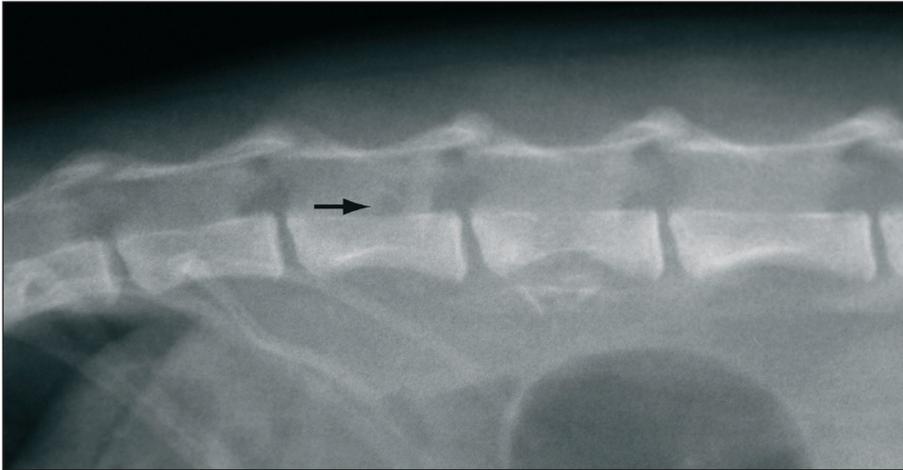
Radiograph of the cranial lumbar spine in right lateral recumbency; the mid portion of the 2nd vertebral body shows a radiolucent area, its transverse process cannot clearly be defined and there are several bony fragments visible within the soft tissue density of the lumbar muscles. There is a focal radiolucent area at the level of the caudal vertebral canal of L1 (arrow). Adjacent to latter there are small areas of increased density. The left 13th rib is fractured.
